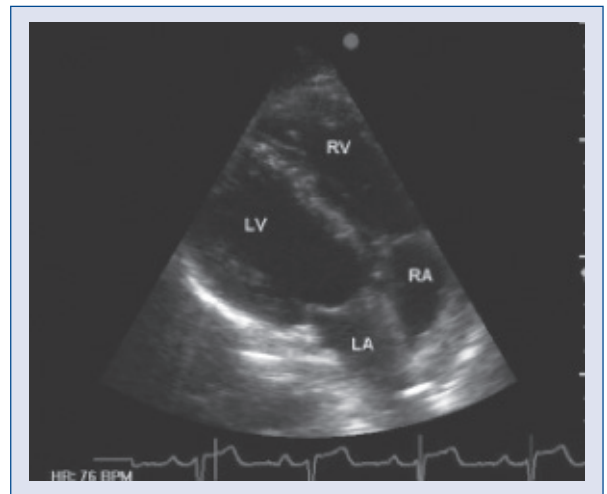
Transthoracic echocardiogram apical four-chamber view showing lateral displacement of the apex and enlarged right ventricle; LA — left atrium; LV — left ventricle; RA — right atrium; RV — right ventricle.
